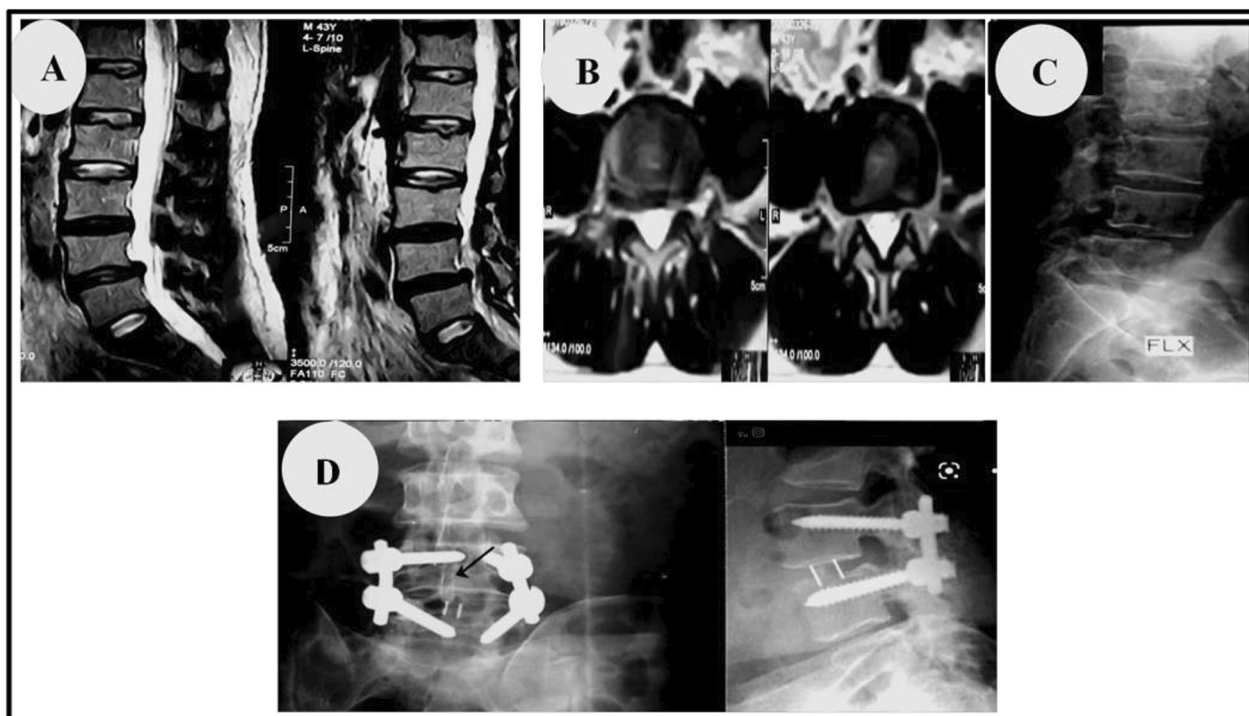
Adult patient above 40 years, presented with low back pain and sciatic pain, was operated by Wiltse Approach. A MRI sagittal view showing slippage at L4-5; B MRI axial view showing pseudo-disc with no significant stenosis; C X-ray showing L4-5 grade 1 slippage with fracture bars interarticularis; D Follow up X-ray (A-P and lateral views) after 3 months with arrow pointing to the cage and the lamina was preserved
